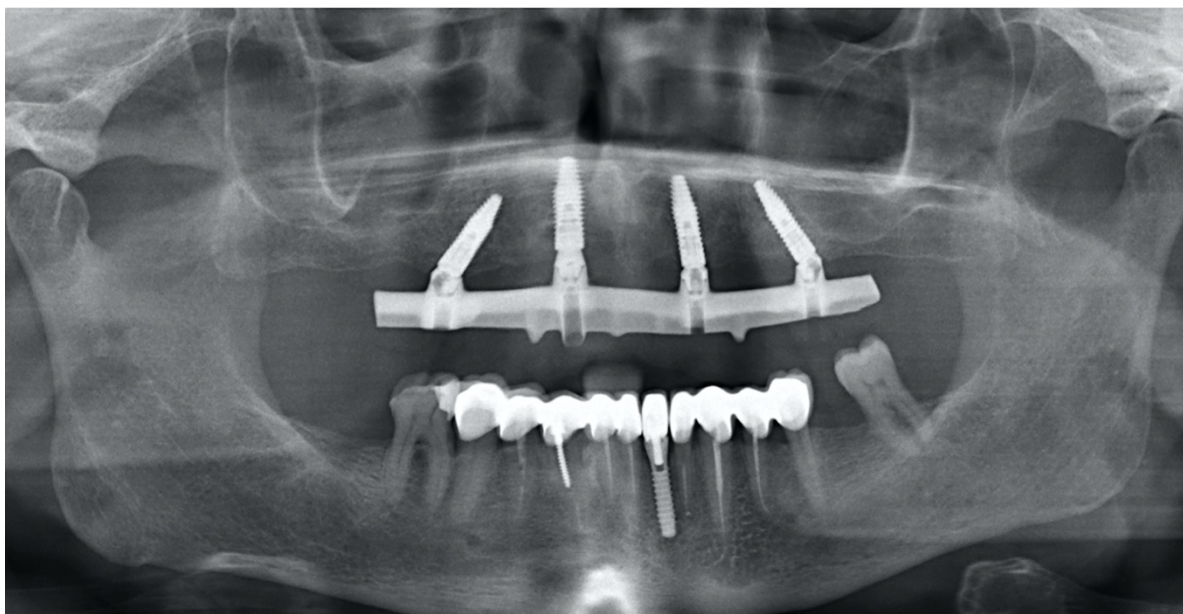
Panoramic X-Ray of the definitive prosthesis.*
